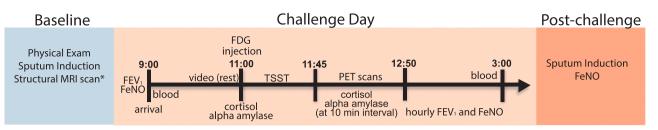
Timing of study visits and measures. This 3 consecutive-day set of visits occurred twice, once for each challenge, with challenge order randomized across participants. *The structural MRI scan typically occurred on the baseline day (day 1), but occasionally was collected on a different day, due to scheduling constraints.
